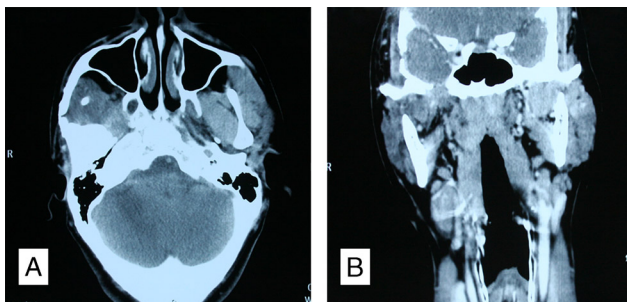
No sign of recurrence of the lesion 8 months after operation, based on CT scan with contrast enhancement: axial image (A) and coronal image (B).
